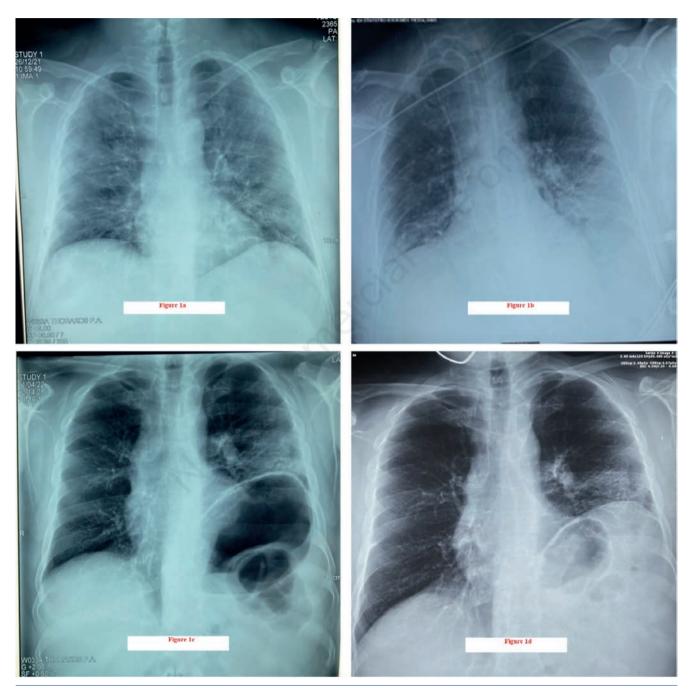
a) Chest X-ray on admission showing presence of parenchymal infiltrations in the lower segments of the left lung, with normal hemidiaphragms position. b) Chest X-Ray performed immediately after the tracheostomy procedure showing presence of worsening parenchymal infiltrations in the lung's lower segments bilaterally, with normal hemidiaphragms position. c) Chest X-ray on three months after hospital discharge, showing significant elevation of the left hemidiaphragm as well as air filled dilatation of the left colic flexure's loops. d) Chest X-ray on nine months after hospital discharge showing persistently elevated left diaphragm.
